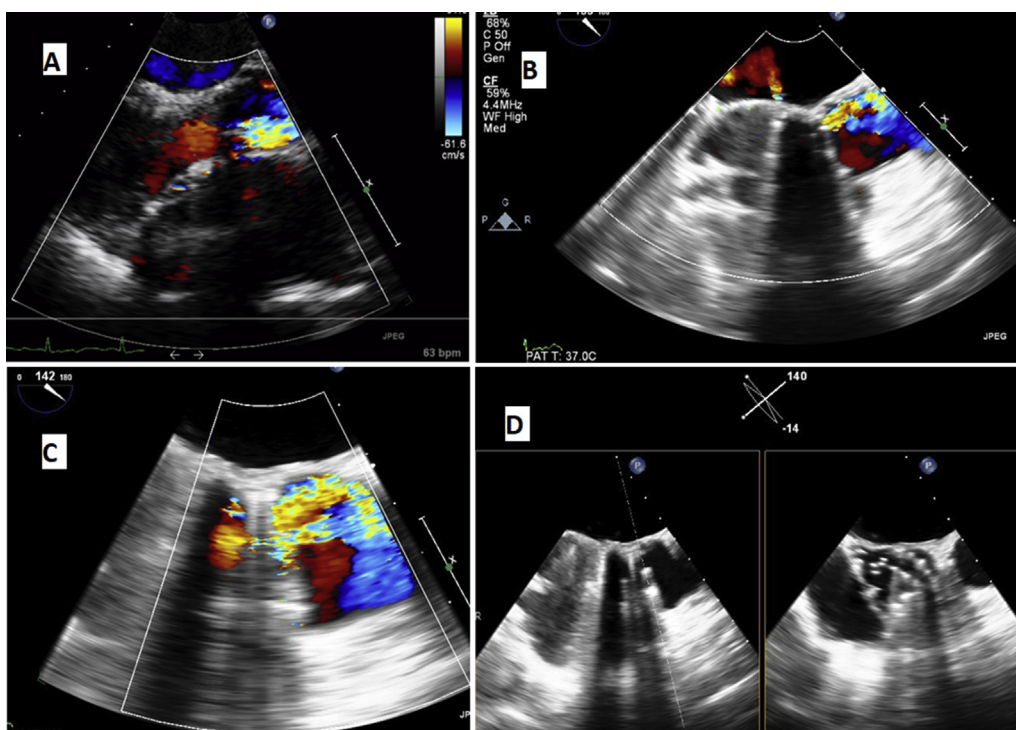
A: TTE parasternal long-axis view, note the flow acceleration at the lower half of the AV while no flow in the upper half. B: TEE LVOT view at 130 degrees, note the accelerated flow in the upper part of AV. C: TEE modified long axis view showed the color flow only from one half of the AV. D: X-plan at LVOT showed one moving AV leaflet.
